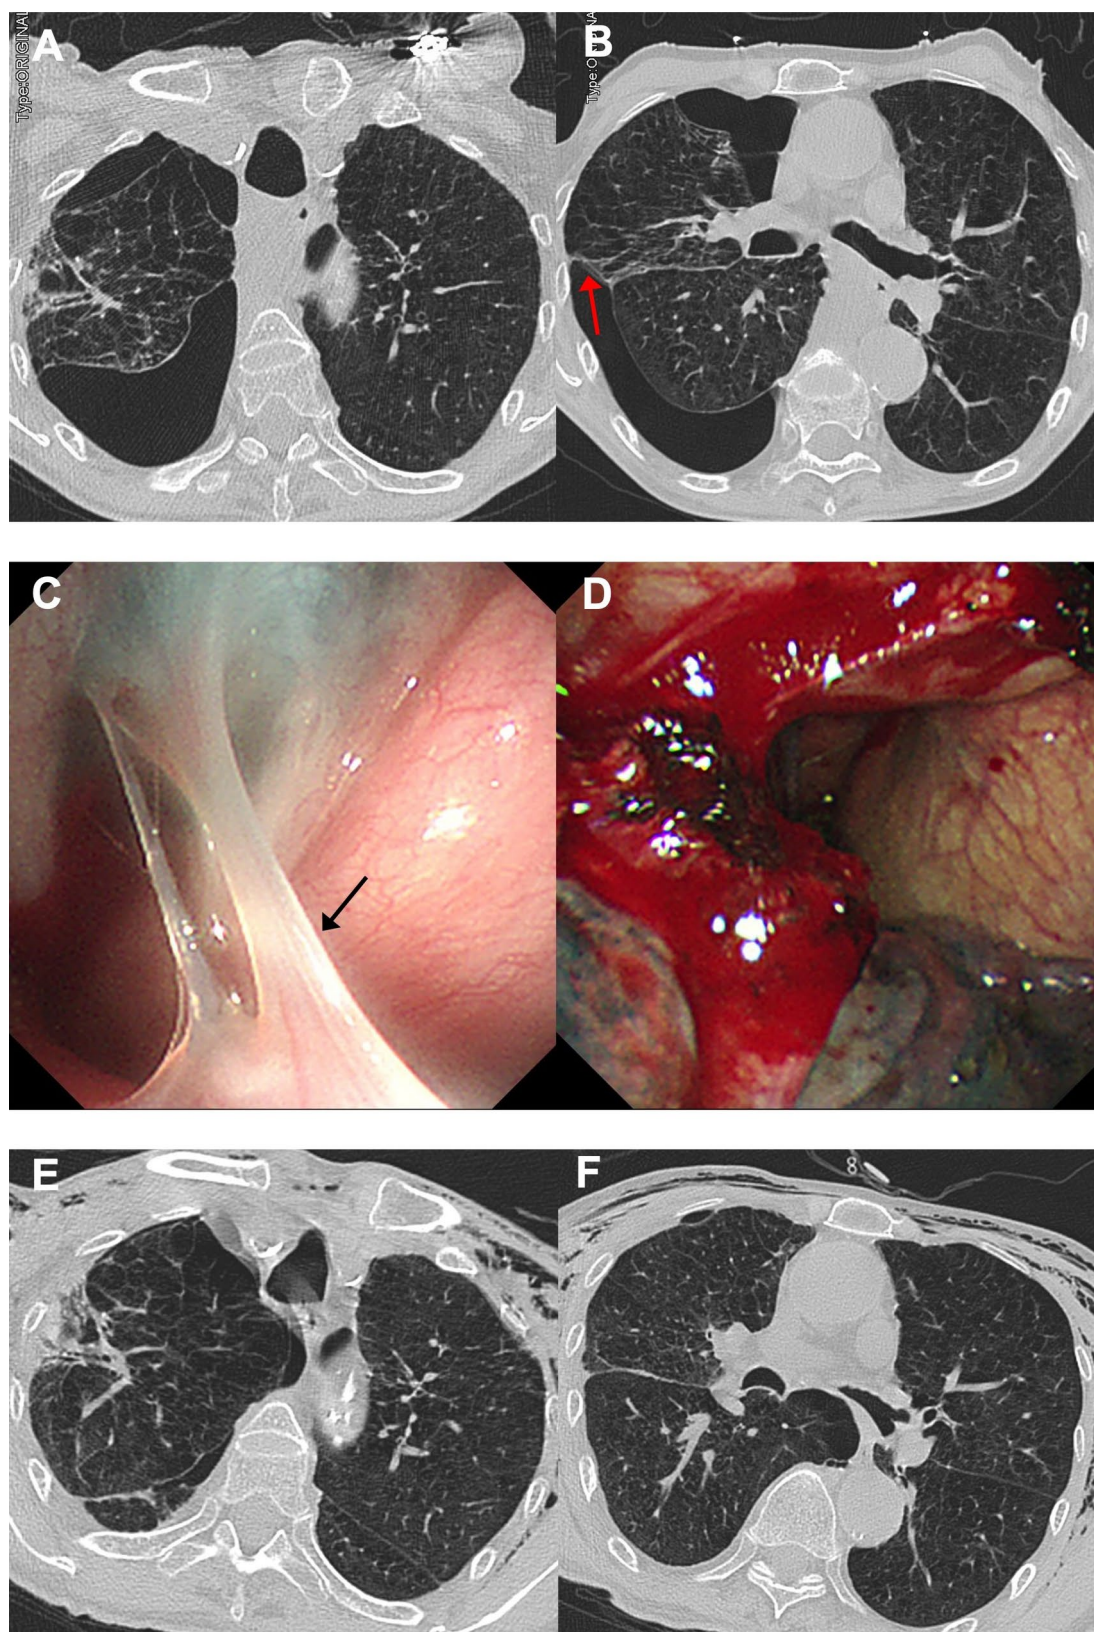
Patient No.5's MT procedure and preoperative/postoperative CT. A, B Preoperative CT, the red arrow indicates pleural adhesions. C MT procedure, the black arrow indicates pleural adhesions. D MT procedure, dissection of pleural adhesions with electrocautery knife. E, F Postoperative CT confirmed lung re-expansion. CT, computed tomography. MT, medical thoracoscopy
